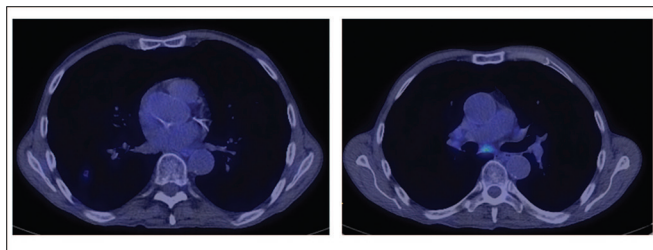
Fluorodeoxy-D-glucose-positron emission tomography (FDG-PET) images at the level of the right lower lobe pulmonary nodule (left panel) and the subcarinal region (right panel) demonstrating minimal fluorodeoxy-D-glucose (FDG) accumulation in the subcarinal adenopathy and the nodule (maximal SUV uptake 1.4).
